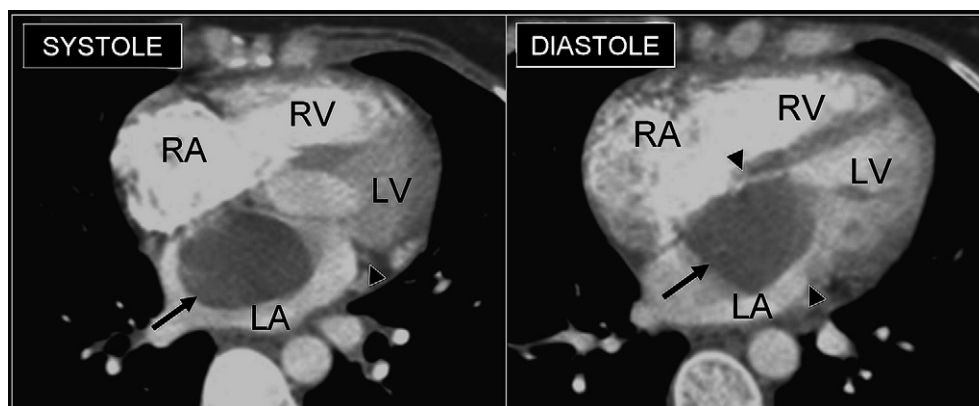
Nongated CT of the chest with contrast in the axial plane from a 37-year-old woman shows a large low attenuation rounded mass in the left atrium attached to the IAS, consistent with a pathology-proven atrial myxoma (arrow). Because of the random phase of acquisition on nongated CT, both systolic and diastolic phases of the cardiac cycle are visualized on the same scan and, in this case, allowing the detection of diastolic prolapse of the myxoma through the mitral valve plane (arrowheads). RA, right atrium; RV, right ventricle; LA, left atrium; LV, left ventricle.
